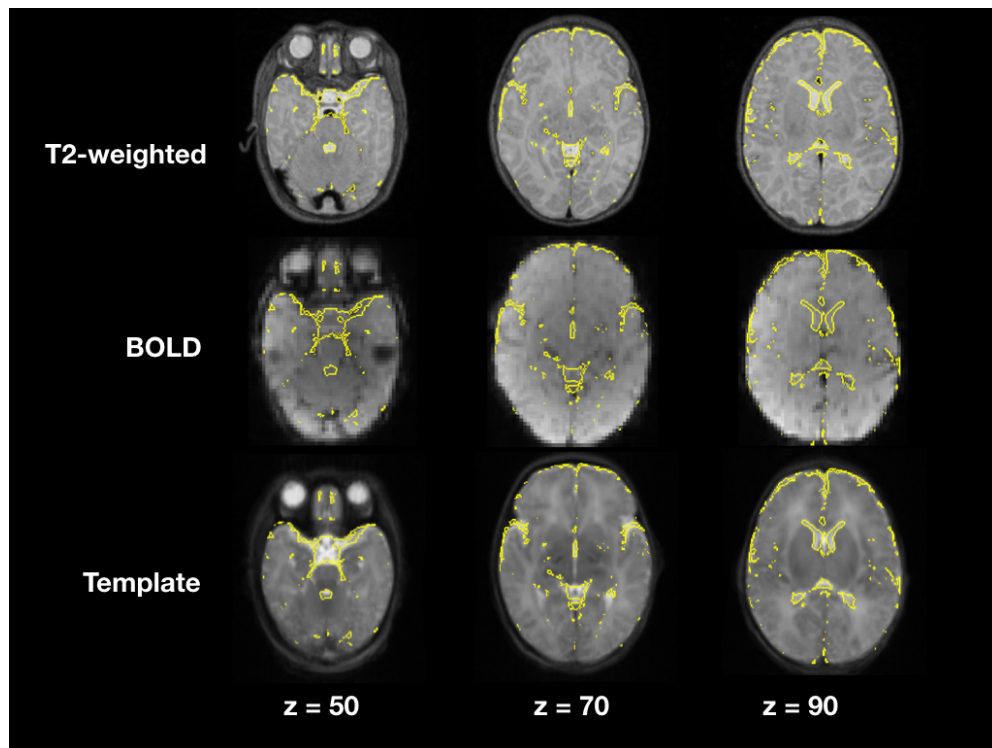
T2-weighted and BOLD image registration to stereotaxic space.
